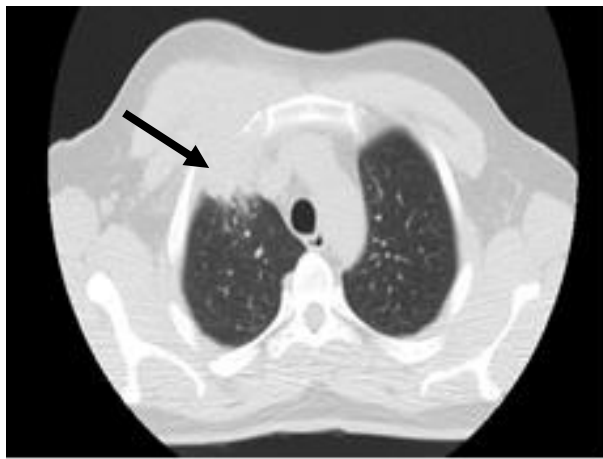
CT image (performed just before the first transthoracic biopsy) of lung mass suggestive of Pancoast tumour (arrow) in pulmonary and mediastinal window.
